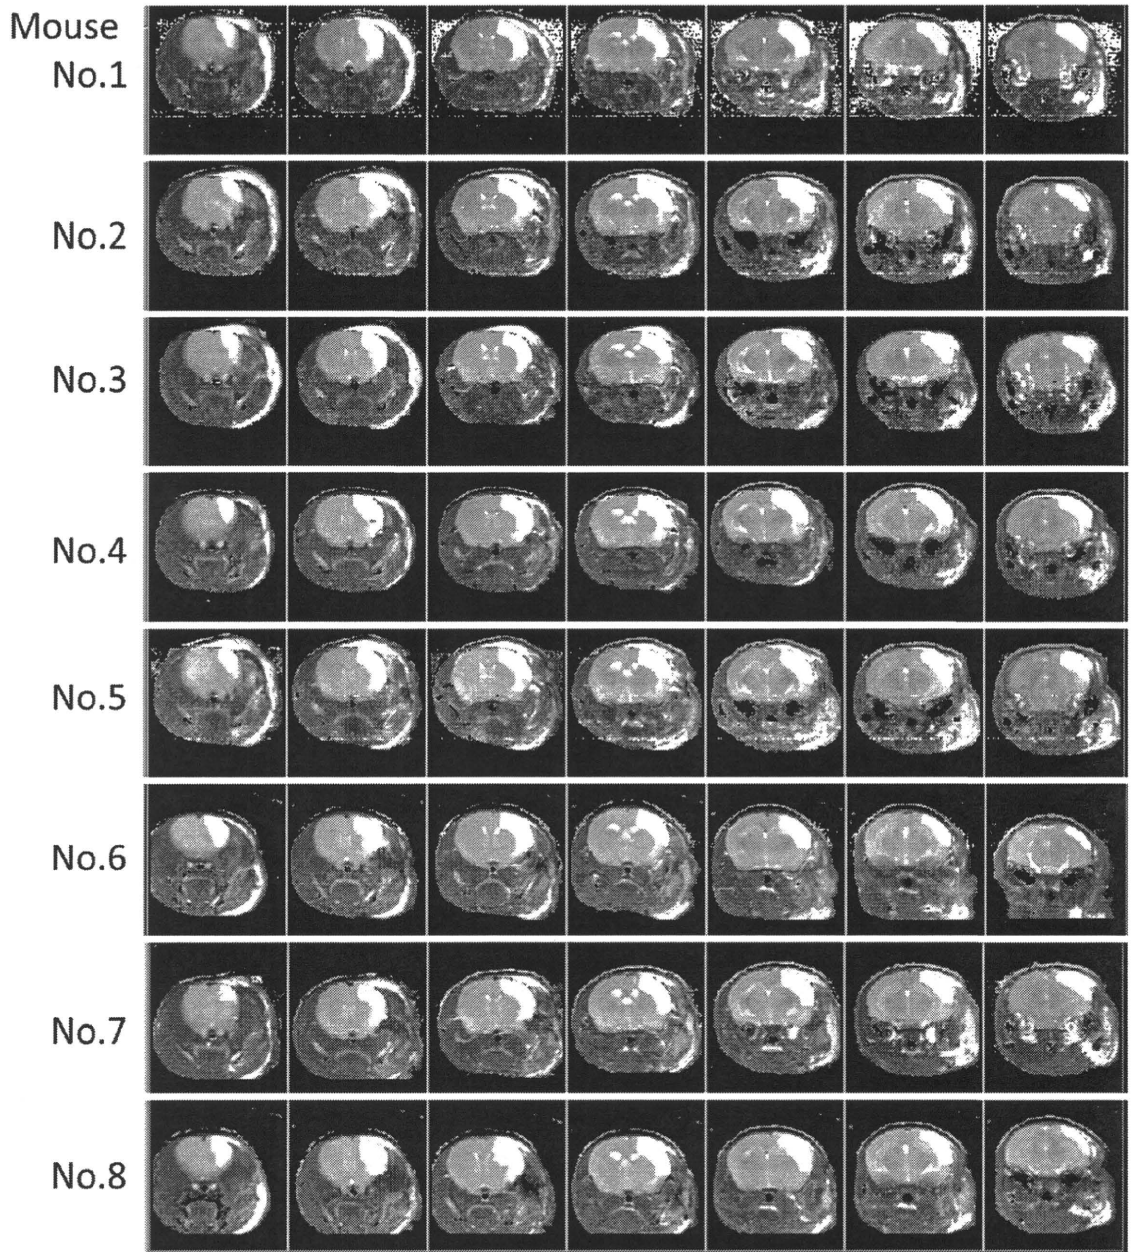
MRI T2 images 24 hours after induction of stroke
